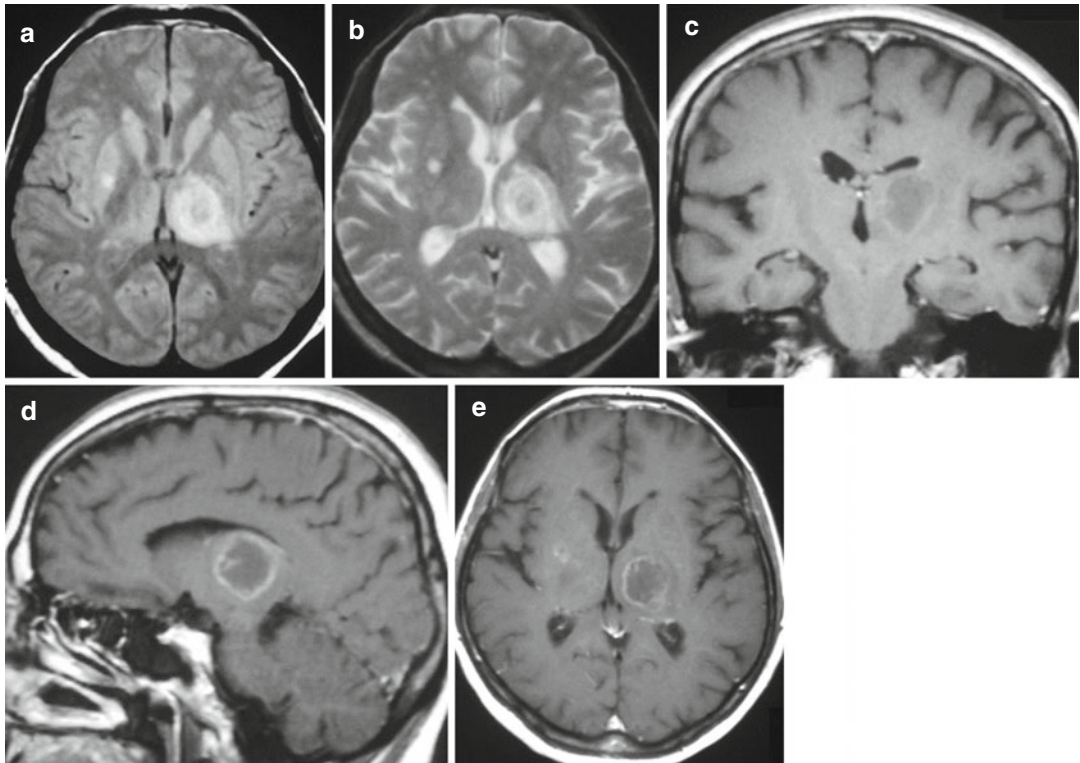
Toxoplasmosis. Axial T2-weighted images (a, b), coronal T1-weighted image (c), and sagittal and coronal T1-weighted images after contrast medium administration (d, e) show a large oval image in the left
